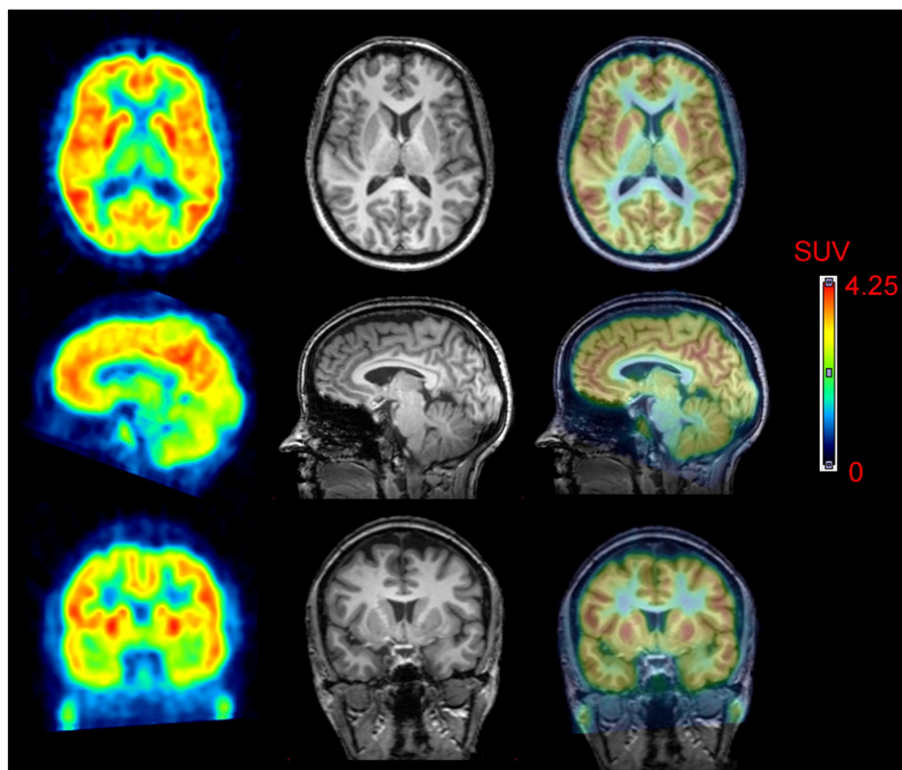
[^{11}C]MePPEP in human brain. PET images from 40 to 80 min after injection of [^{11}C]MePPEP were averaged (left column) and coregistered to the subject's MRI (middle column). PET and MR images are overlaid in the right column.
